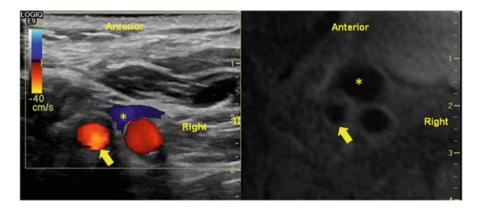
Real-time B-mode ultrasound scan with color Doppler (*left*) of a carotid bifurcation co-registered to corresponding MR image set (*right*). *Arrows* indicate the internal carotid artery, and the *asterisk* indicates the internal jugular. A difference in scale between panes exists
